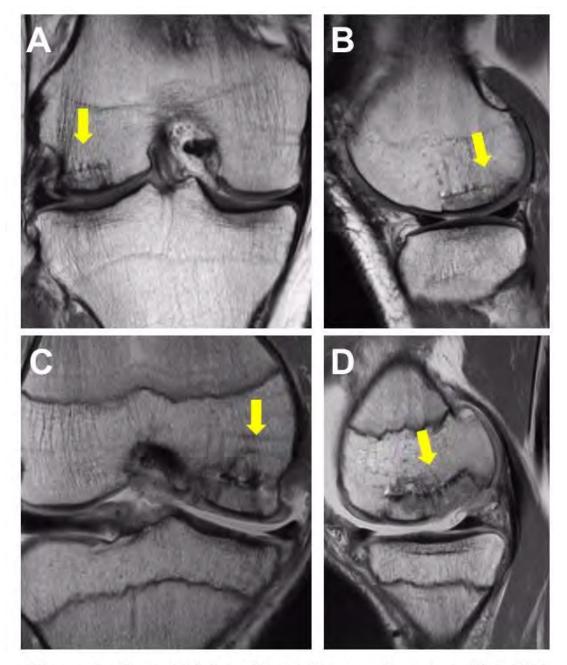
Representative 12-month coronal and sagittal MRI sections in a (A,B) 20-year-old male, demonstrating crossing trabeculae and minimal subchondral marrow edema, and (C,D) 16-year-old-male, demonstrating discernible clefts at the host-graft junction and significant subchondral marrow edema. Both were treated with BMAC+OCA.
